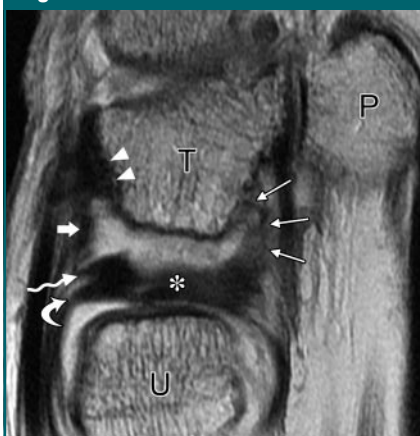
Sagittal intermediate-weighted MR image shows anatomic features of the UMH slightly ulnar to the origin of the dorsal radioulnar ligament (curved arrow) and radioulnar component (wavy arrow) of the UMH. The radioulnar component extends to the distal contour of the dorsal radioulnar ligament. The TFC is marked with an asterisk. The ulnotriquetral ligament is noted as a thickening of the dorsal joint capsule (thick arrow). The insertion of the radiotriquetral ligament (arrowheads) is seen in the dorsal aspect of the triquetrum (T). On the volar side, the distal insertion of the UMH is seen with its main body (thin straight arrows) attaching to the triquetrum. P = pisiform, U = ulna.
